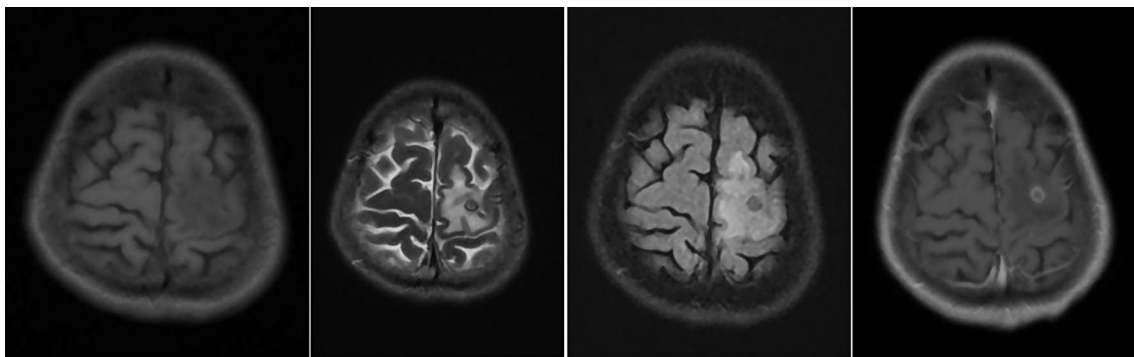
Head MRI scan. The head MRI revealed a nodular abnormal signal in the left frontal lobe, with slightly high signal on T2-weighted images and slightly low signal on FLAIR images, surrounded by patchy edema. The lesion in the left extraocular muscle area exhibited a low signal
